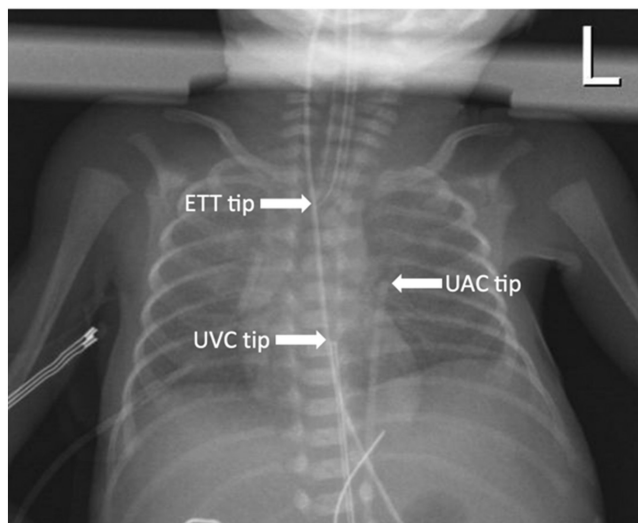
Initial radiograph showing the UVC position.
